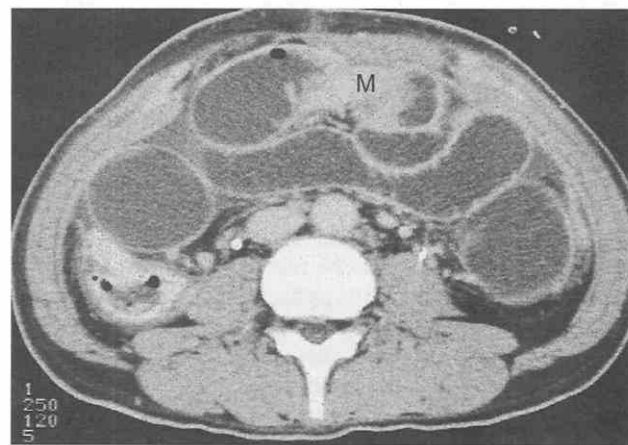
Malignant small-bowel obstruction due to peritoneal tumor seeding after surgery for gastric cancer. CT scan shows irregular mass (M) obstructing the small-bowel loop. (From Ha HK, Shin BS, Lee SI, et al: Usefulness of CT in patients with intestinal obstruction who have undergone abdominal surgery for malignancy. *AJR Am J Roentgenol* 171:1587-1593, 1998.)
